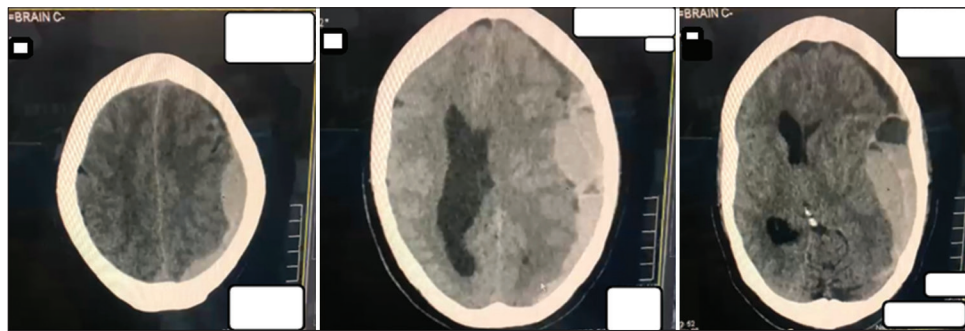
Axial cuts of patient’s preoperative noncontrast CT scan in the morning October 24, showing extensive left subdural hematoma with significant midline shift, ipsilateral ventricular obliteration, contralateral ventricular dilation.
